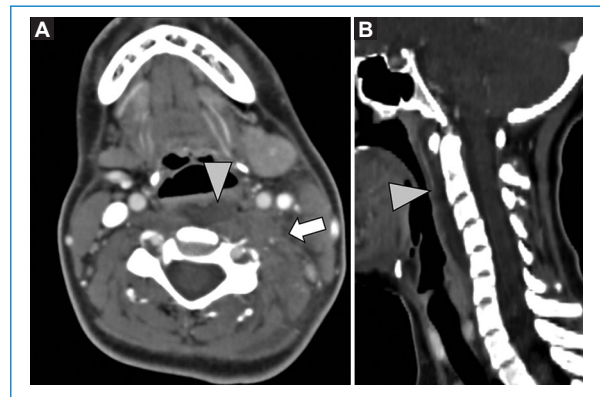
Contrast-enhanced computed tomography, axial (A) and sagittal (B). Left paravertebral inflammatory process (arrow) and increased volume of the retropharyngeal space (arrowhead). Purulent content and edema in the retropharyngeal space cannot be differentiated.
